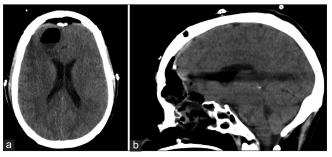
(a) Axial CT after skull base reconstruction to seal postoperative defect in anterior cranial base, (b) Sagittal plane of the same scan.
